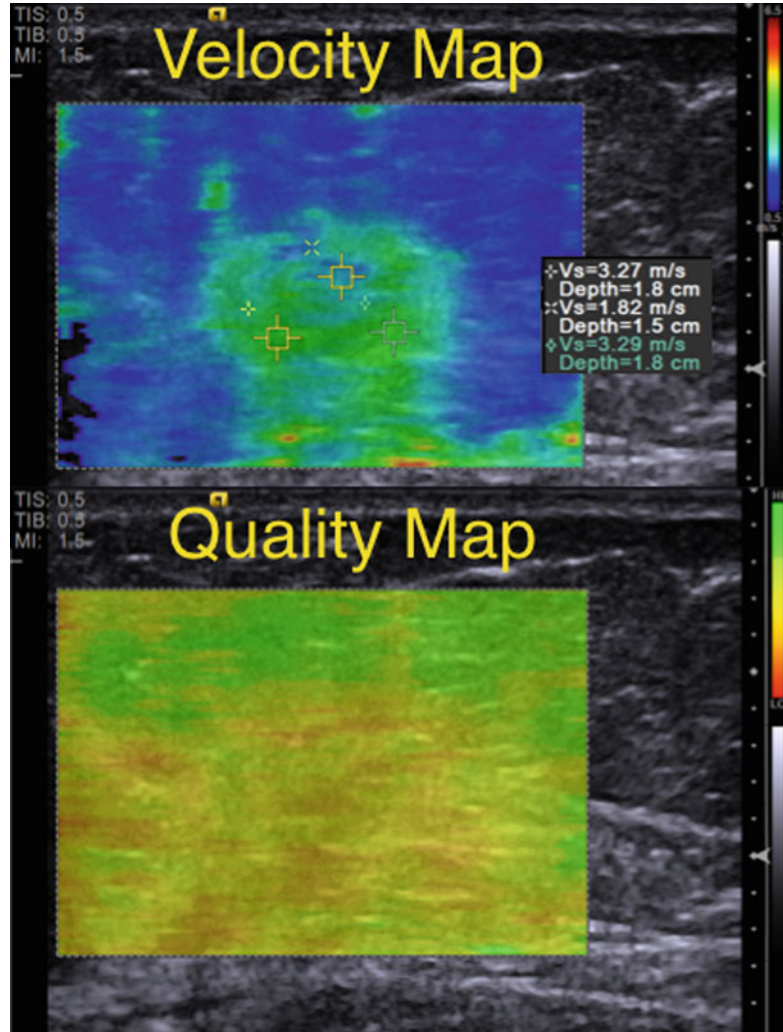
Results from a 57-year-old woman with a palpable mass in her right breast. Mammographic and sonographic workup confirms a BI-RADS 4B lesion. The lesion is a biopsy-proven poorly differentiated invasive ductal cancer. The cancer is the hypoechoic mass in the deeper portion of the image. Two waveforms were obtained using the acoustic radiation force impulse technique.
